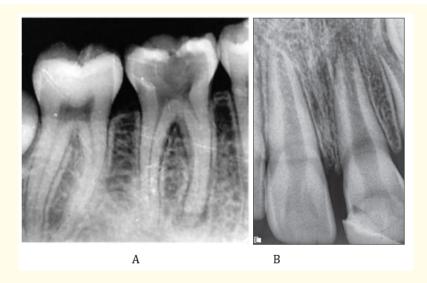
Showing A) Periapical radiolucency at the mesial root of molar. B) Periapical rarefaction suggestive of acute periapical abscess [9,10].
